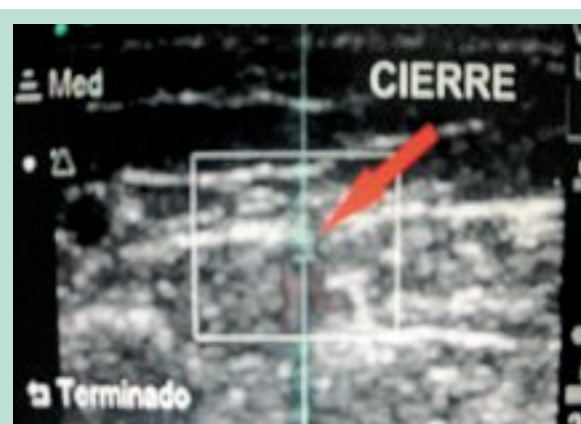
Echo-Doppler control of the same case once finished the closure of the perforating vein with percutaneous laser.
